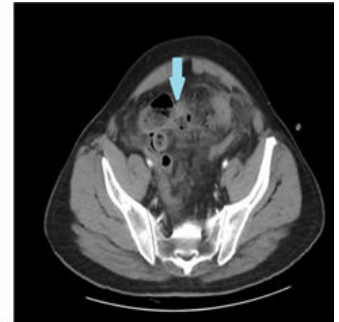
B- Computed Tomography image: Transition point at distal ileum with contained perforation
